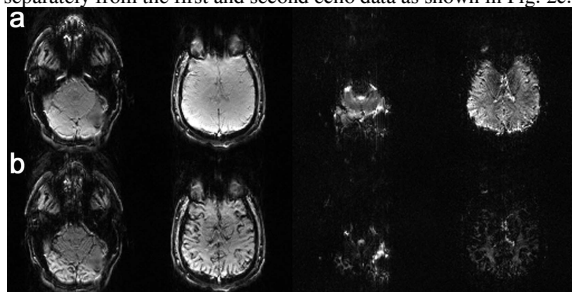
Reconstructed MR images at the (a) 10-th and (b) 30-th temporal scans. In each row, the two left and two right images were obtained from the 1st and 2nd echo data, respectively. (c) AIF obtained from the carotid and venous region with DC-EPIK ( $AIF(t) = -1/TE \cdot S(t)/S_{baseline}$ ) and <sup>18</sup>F-FET (curves normalized to the maximum of each curve, which was different for each curve). Curves are shown from 10 seconds after injection.
